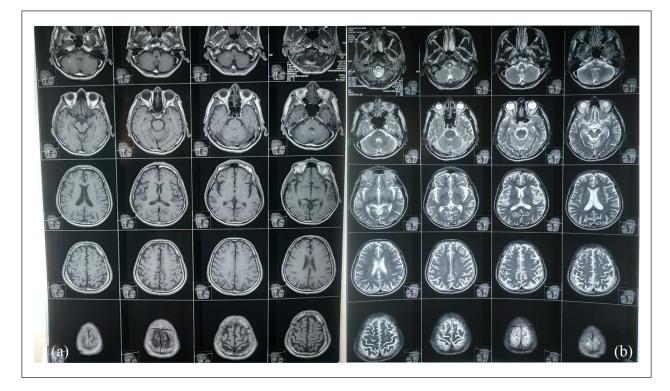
TI-weighted axial (a) and T2-weighted axial (b) brain magnetic resonance imaging showing multiple discrete confluent T2 high signal intensity noted in bilateral periventricular white matter and centrum semiovale along with prominent extra axial cerebrospinal fluid space with proportionate dilatation of ventricles giving impression of age-related small vessel disease and age-related cerebral atrophy.
